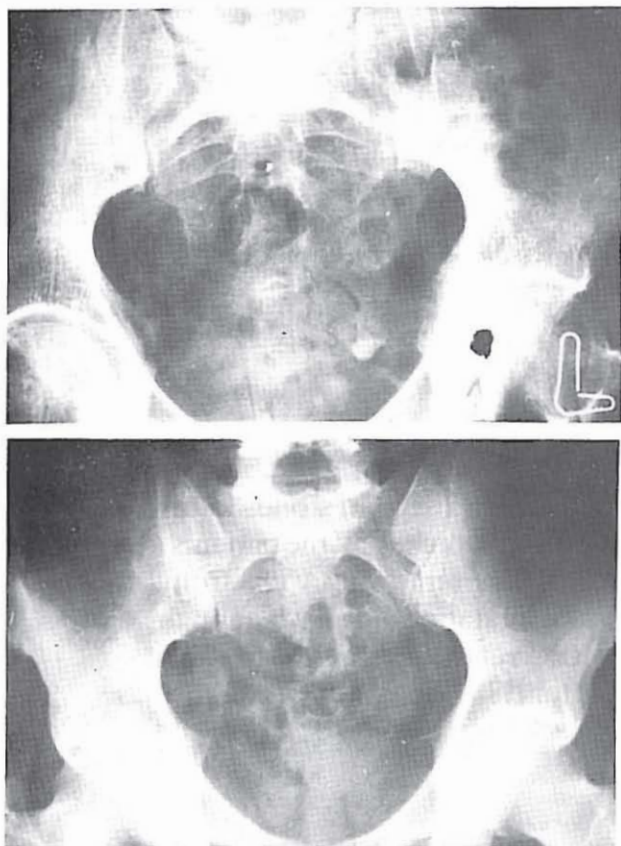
A, pelvic radiograph demonstrating left lower ureteral stone. Arrow points to stone which was removed en bloc.
